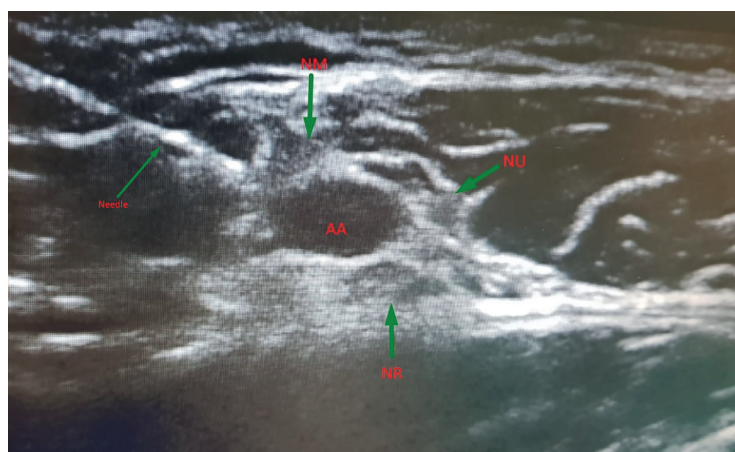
This image described the axillary nerve blockage. Once axillary artery flow was demonstrated, 24-gauge stimulation needle advanced in-plane over skin with an angle of 45 degree. When the needle was seen by ultrasound, 10 cc %0.250 15 mL bupivacaine and 15 mL 1% lidocaine was applied each three separate points, radial ulnar and median nerve root, around axillary with a total amount of 30 mL anesthetic solution (AA: Axillary artery, NM: Nervus medianus, NR: Nervus radialis, NU: Nervus Ulnaris).
